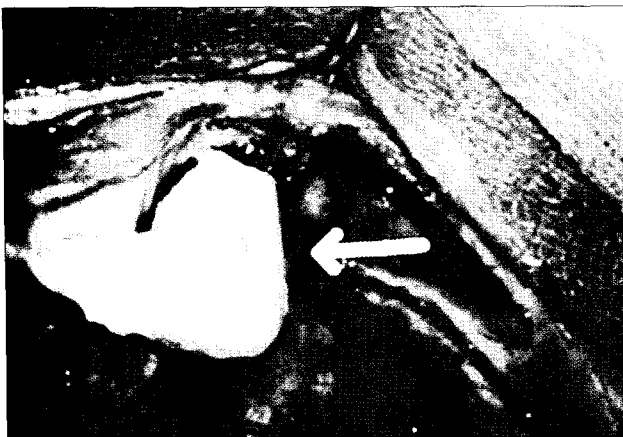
Computed tomography of paranasal sinus demonstrates high attenuation lesion in the left frontal sinus (white arrow). Its finding was compatible with paranasal sinus osteoma.
